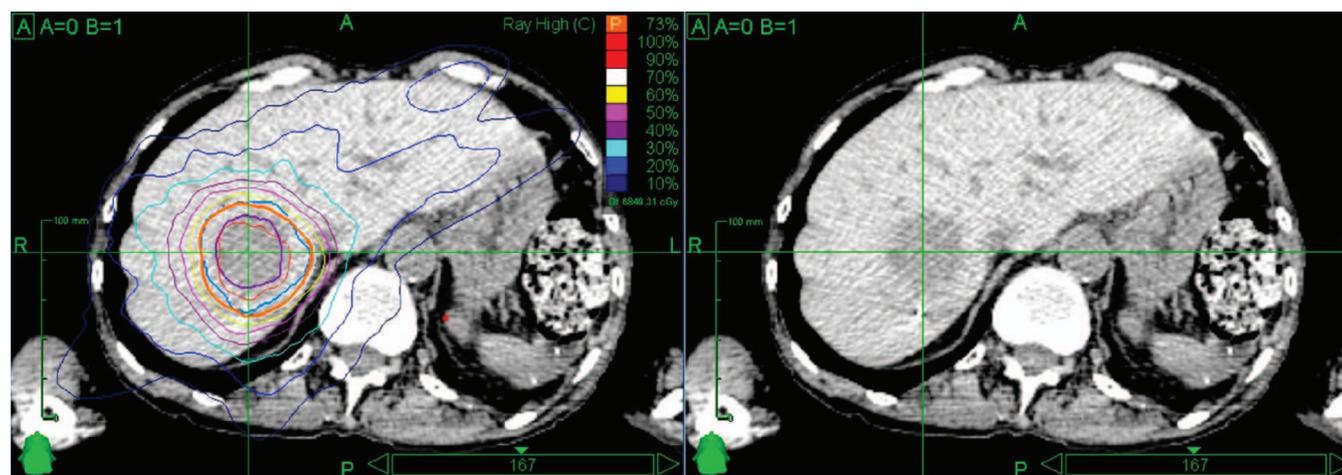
Axial CT image from stereotactic body radiotherapy (SBRT) treatment planning system with colored isodose lines (left) and without (right). Each line represents a three-dimensional calculated absorbed dose of radiation. Note the tightly conformed high-dose lines around the tumor, with rapid fall off of radiation dose in the normal liver tissue only a short distance away. This patient received 50 Gy in five fractions of 10 Gy for metastatic colon cancer lesion. At 12 weeks post-SBRT, the lesions was necrotic and lacked enhancement with IV contrast. The patient did not experience any side effects or late toxicity.
